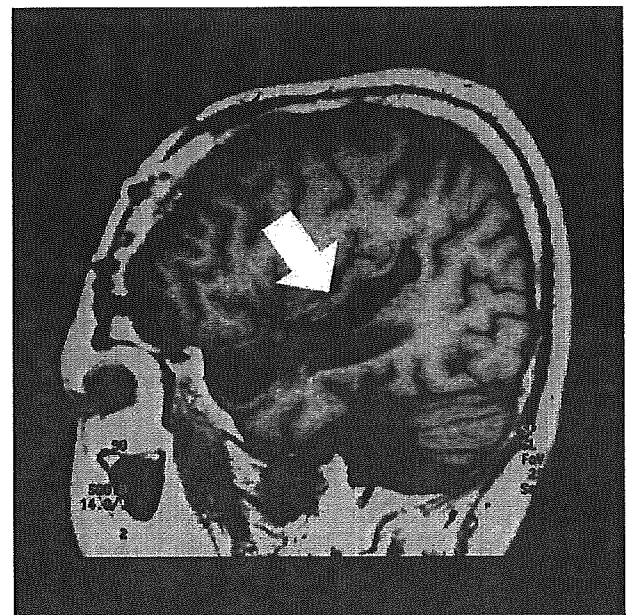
MRI scan of M.J.'s lesion. A rare lesion almost completely circumscribed to the entire right STG, which is indicated by the arrow, is shown in a sagittal slice.
